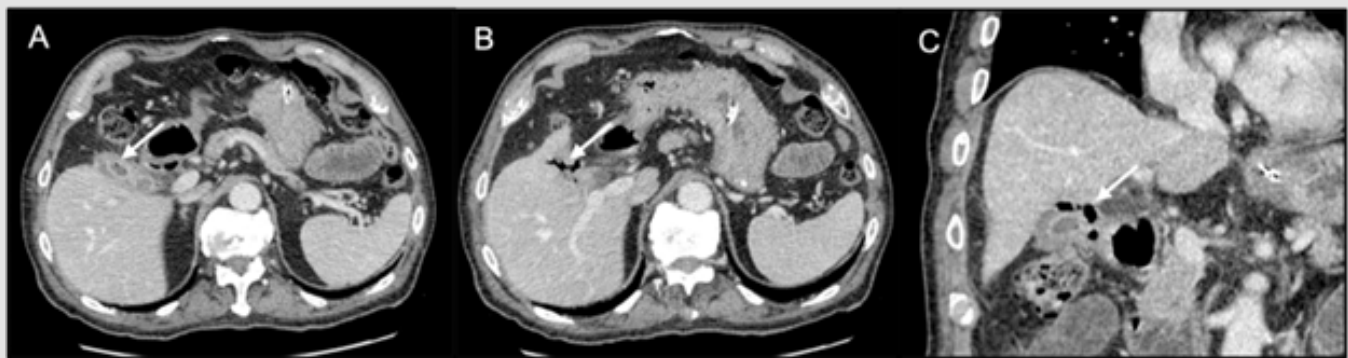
axial contrast-enhanced CT image shows a punctiform air bubble in the lumen of the gallbladder (arrow). B: axial contrast-enhanced CT image demonstrates air surrounding the gallbladder (arrow). C: coronal CT reconstruction shows the presence of air surrounding the gallbladder (arrow).
